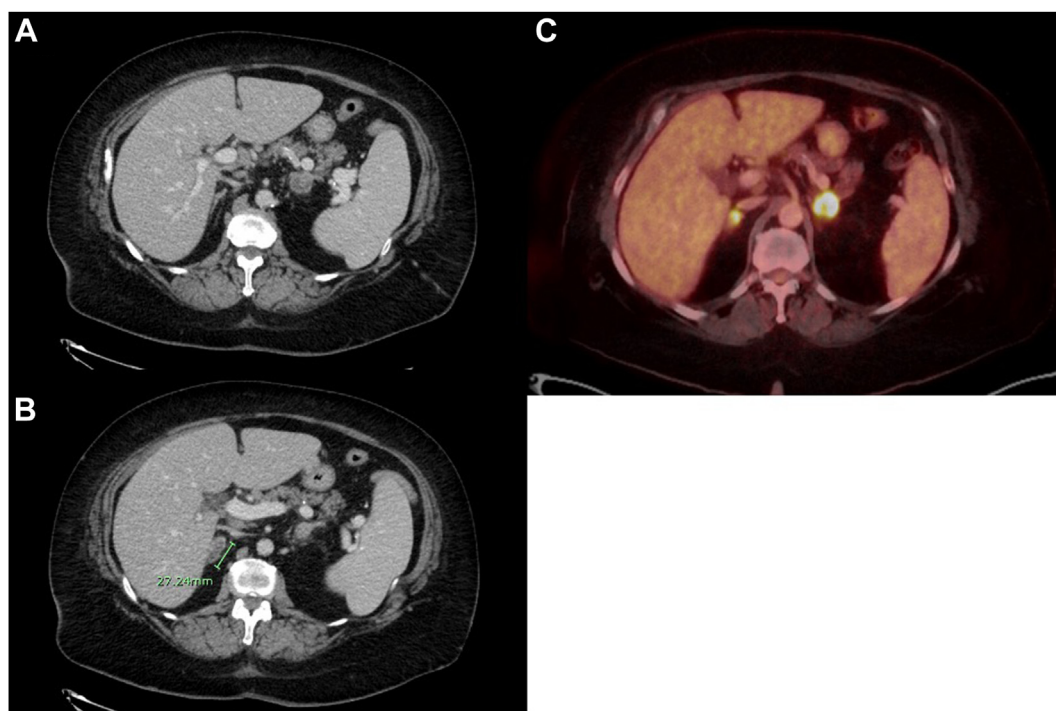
Postchemotherapy cross-sectional imaging for patient A demonstrating bilateral adrenal nodules. A, Right adrenal nodule measuring 2.6 cm. B, Left adrenal nodule measuring 3.7×2.2 cm. C, Positron emission tomography/computed tomography showing bilateral fluorodeoxyglucose-avid adrenal lesions.
